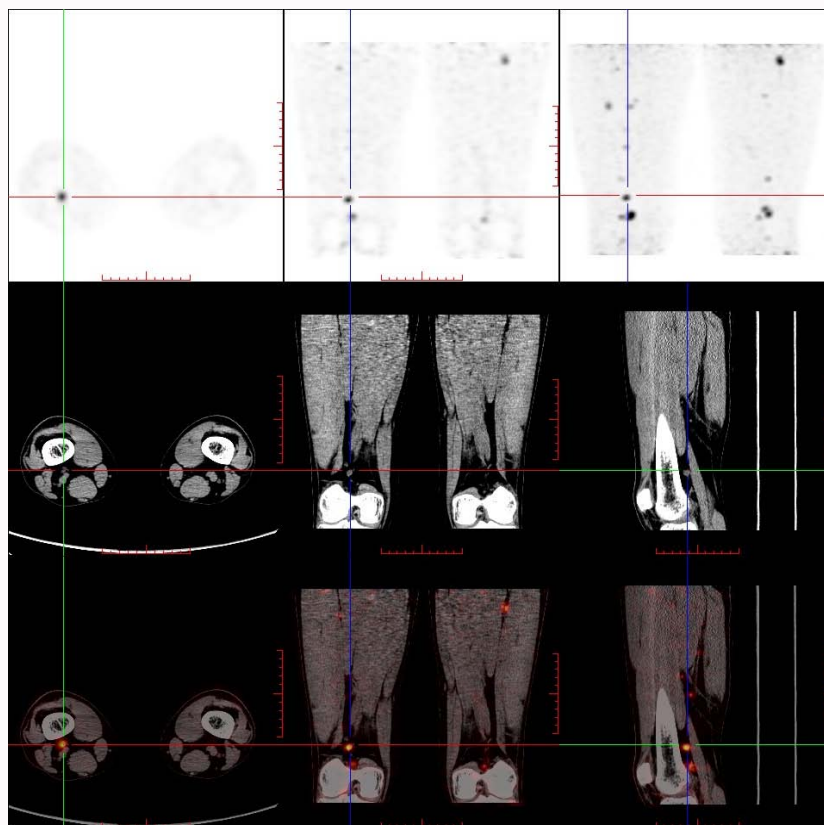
^{18}F -FDG PET/CT in a 25-year-old male with systemic TB: Intermuscular lymph nodes of the lower extremities (SUVmax=13.9).
